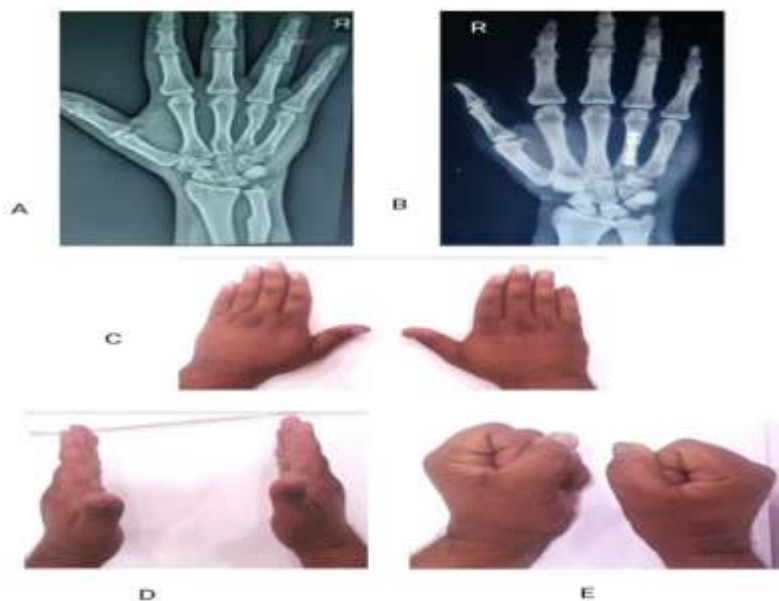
A) Preoperative xray showing 4th metacarpal middle 1/3rd fracture, B) Postoperative xray showing 4th metacarpal fracture treated by Miniplate and screws, C,D,E) Clinical ROM pictures of the patient at final followup.
